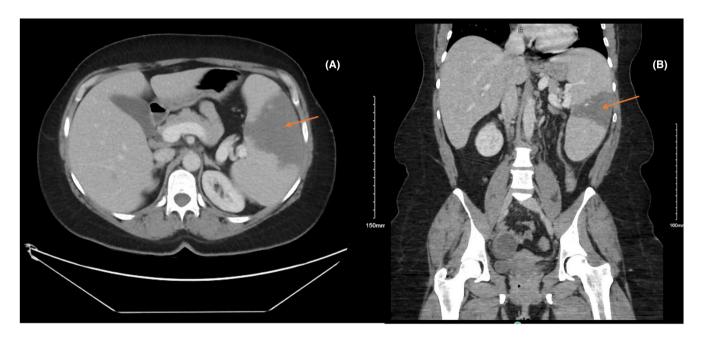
CT of the abdomen done on her second hospitalization in November 2022. (A) axial view and (B) coronal view of the abdomen showing splenomegaly and a large splenic infarct. The orange arrows point to a hypodensity within the enlarged spleen, which represents the splenic infarct.
